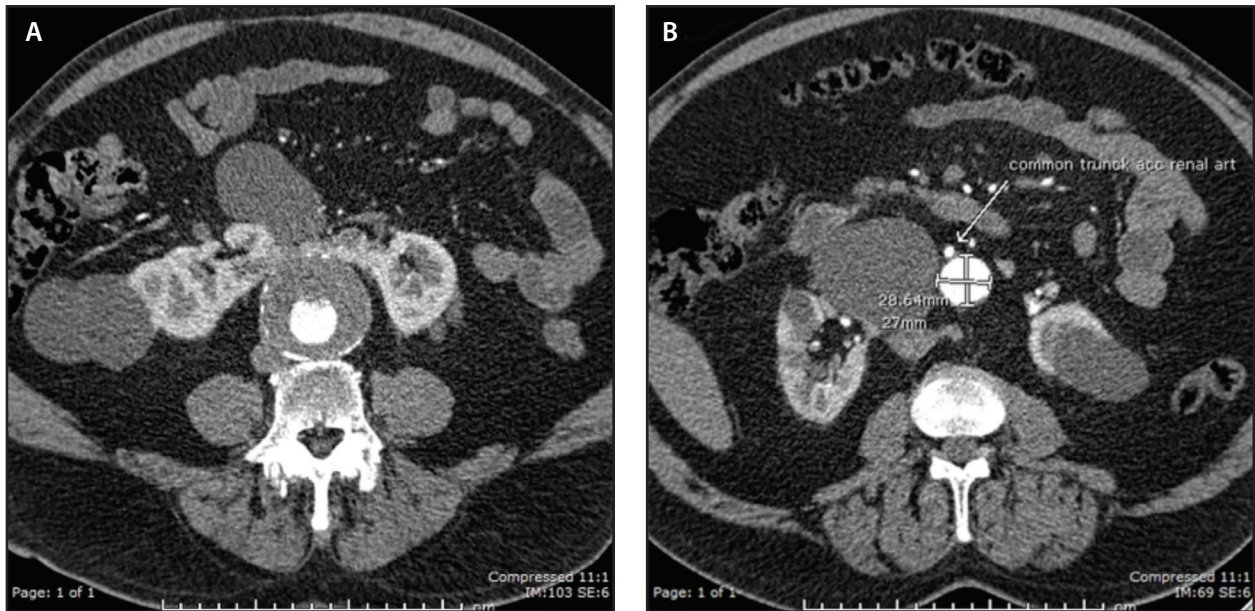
Preoperative CT (axial view) revealed a 6.1-cm AAA and HSK (A). The accessory renal artery is shown in (B).
